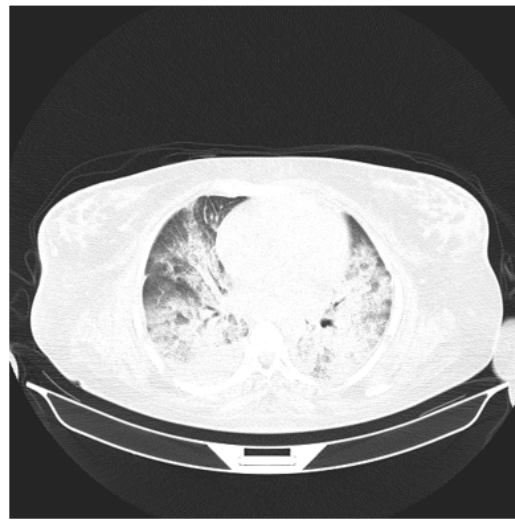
Case 1: Thorax CT.
